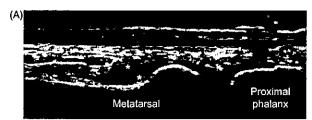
Representative images of non-specific thickening of synovial membrane. Dorsal aspect of metatarsophalangeal joint in the right first toe, longitudinal view. (A) gray-scale image and (B) power Doppler image. Asterisks indicate non-specific thickening of synovial membrane.
